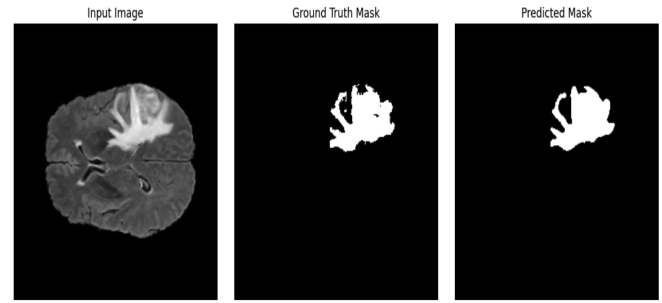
MRI Image with Training and Prediction.
